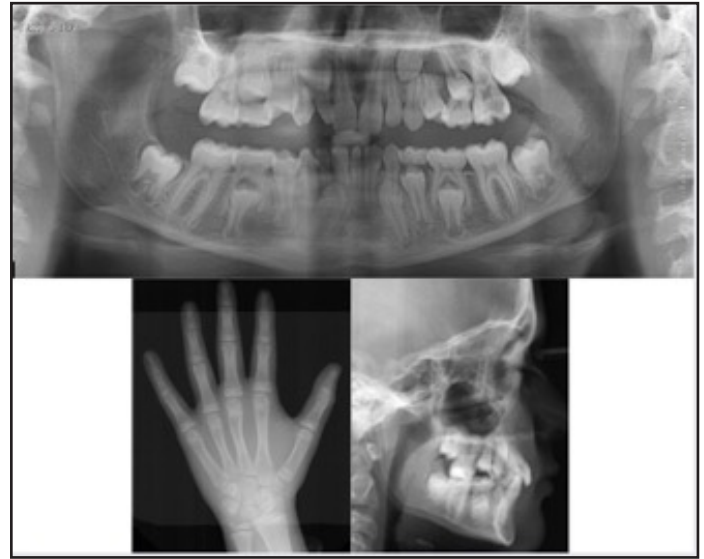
Panoramic radiograph , cephalometric radiograph and hand-wrist radiograph of case 1
